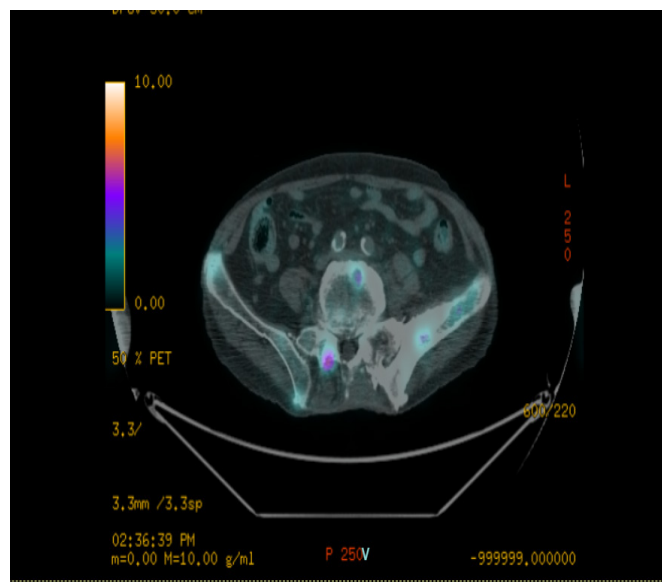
PET/CT cross-section
